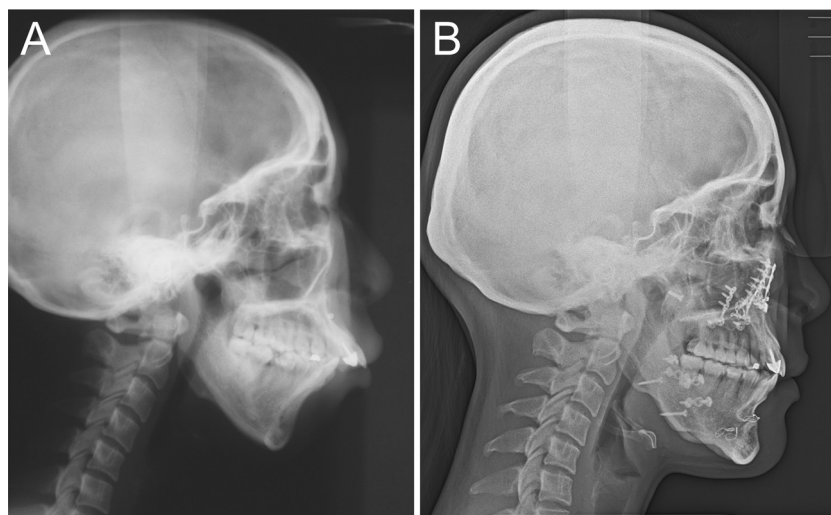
(A) Preoperative and (B) postoperative cephalometric radiographs demonstrating significant improvement in pharyngeal airway, facial profile, and dental occlusion after modified MMA (i.e., Le Fort I segmental osteotomy, bilateral sagittal split osteotomy, and reversed-T mandibular osteotomy with counter-clockwise rotation). Note the screw for fixation of an unexpected fracture of the pterygoid plate.
